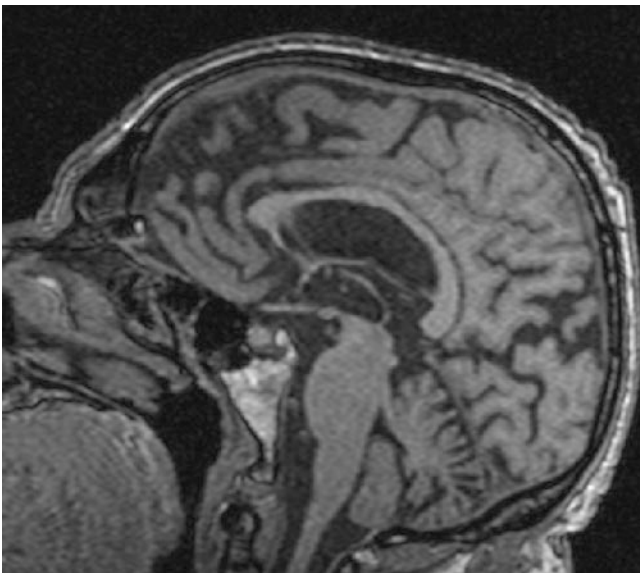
Alzheimer's disease. MRI T1 Sagittal. Showing atrophy of precuneus (and posterior cingulate to a less degree). (Reproduced with kind permission from Dr. Lisa Tarlinton and courtesy of Nepean Hospital)
